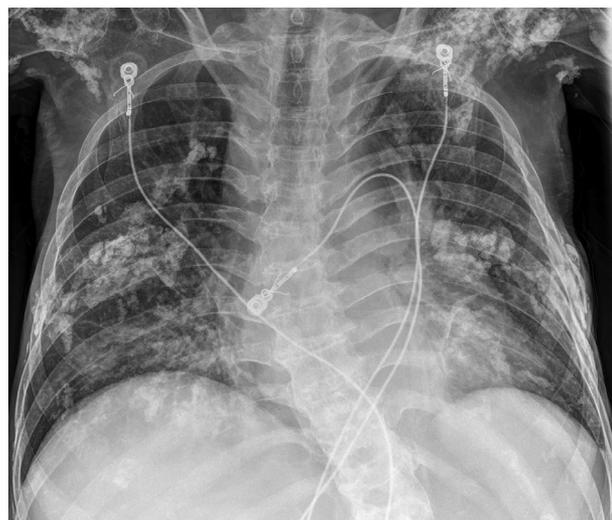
A 45-year-old female with longstanding dermatomyositis. Frontal chest radiograph shows extensive soft tissue calcinosis.
